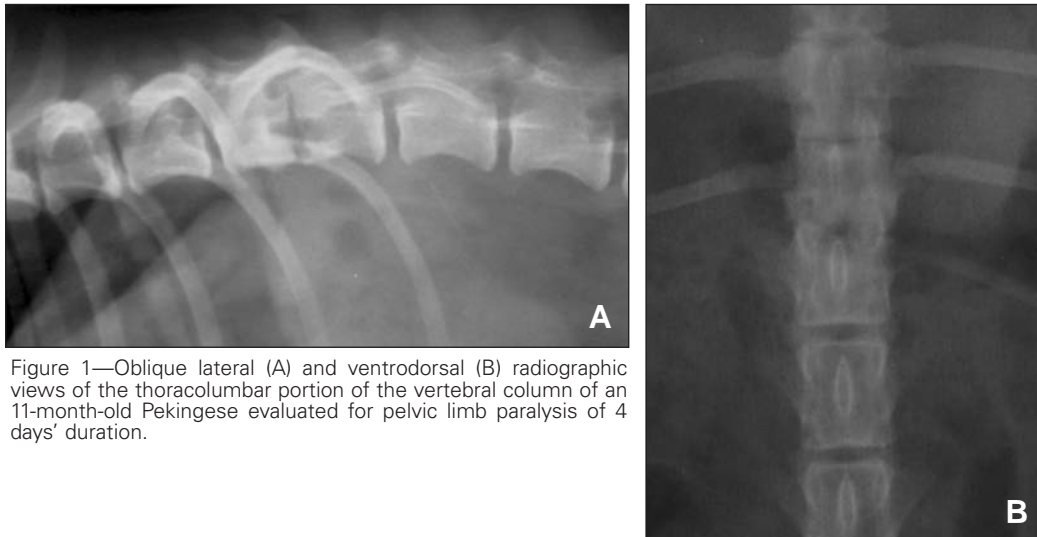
Oblique lateral (A) and ventrodorsal (B) radiographic views of the thoracolumbar portion of the vertebral column of an 11-month-old Pekingese evaluated for pelvic limb paralysis of 4 days' duration.
